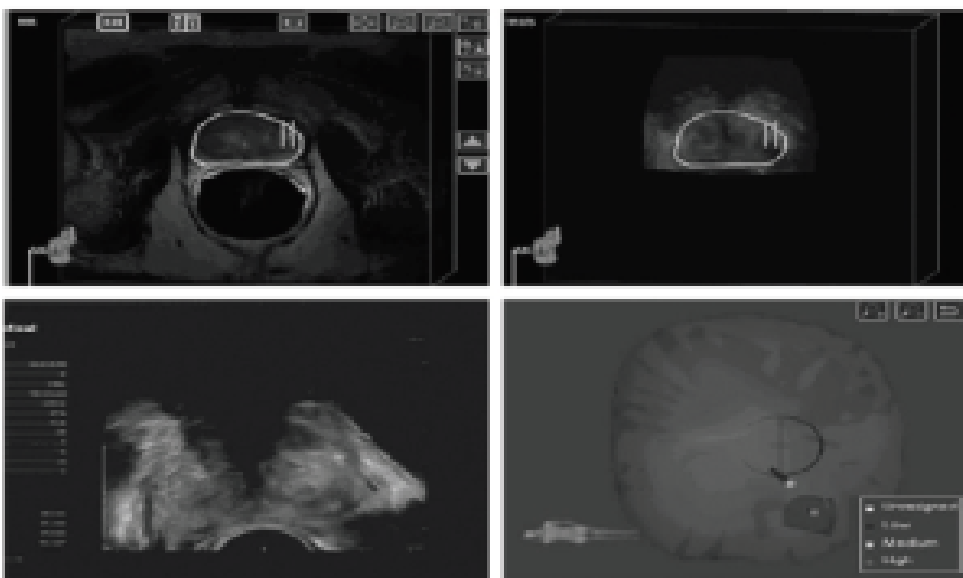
MRI-Fusion biopsy with planned biopsy targets.
